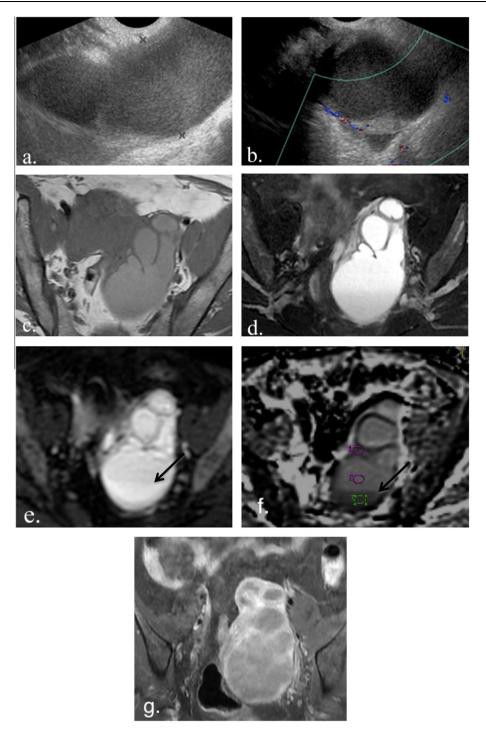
Tubo ovarian abscess: a 36 year old female patient presented with pelvic pain and fever. Pelvic ultrasound (a & b) revealed a left adnexal multiloculated cystic lesion with low-level internal echoes and minimal amount of free fluid. It was interpreted as an ovarian cystic mass for differential diagnosis. (c & d) Axial T1 and T2 fat sat weighted image revealed a left adenexal multilocular cystic lesion that reflects bright signal on T1 and T2 fat sat weighted images. (e & f) Axial diffusion weighted image and the corresponding ADC map revealed significant diffusion restriction with low ADC value, subtle fluid-fluid level was seen (arrows) denoting abscess formation; mean ADC value measured was 2.8×10^{-3} . (g) This was confirmed in the axial post contrast T1 weighted images with fat saturation that revealed thick marginal moderate contrast uptake.
